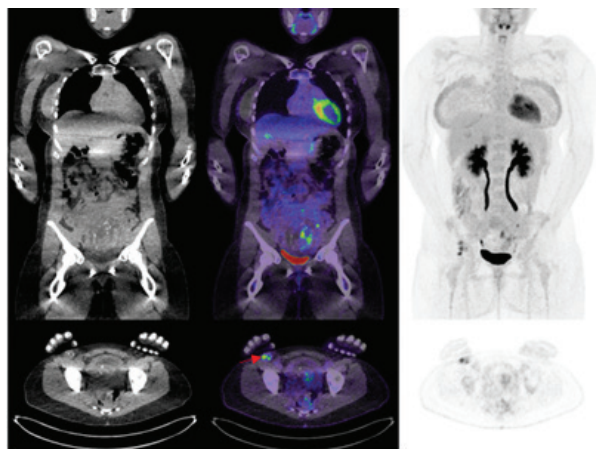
33-year-old female (73kg), 16 weeks pregnant. Referred for assessment of recurrence of melanoma presenting with new enlarged inguinal lymph node (red arrow) on a background of resected stage IIIa BRAF mutant melanoma. Patient received radiation counselling for potential foetal risk and written consent was obtained. 116 MBq [¹⁸F]FDG was administered, CT for attenuation correction was acquired using parameters 100 kVp and 20 mAs. Estimated foetal dose was calculated to be approximately 3 mGy. Due to reduced administered [¹⁸F]FDG activity, FDG PET image acquisition time was increased by factor 2. Increased hydration and voiding were recommended. Note beam-hardening artefact due to arms positioned down. Images acquired using Siemens Biograph Vision 600 Edge digital PET/CT scanner.
